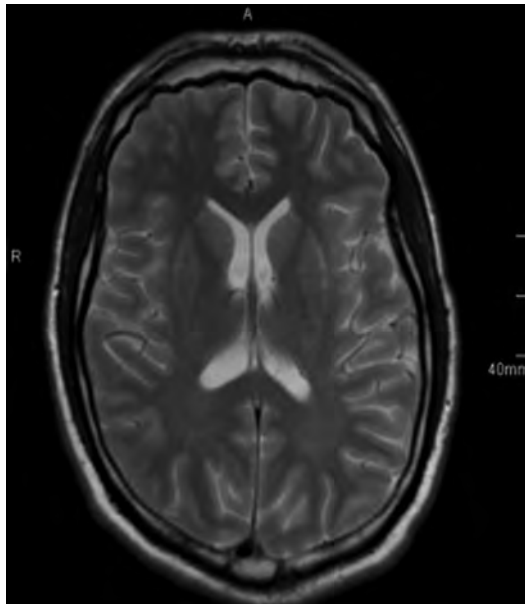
T2-weighted MRI shows bilateral basal ganglia lesions in a patient with carbon monoxide poisoning.
